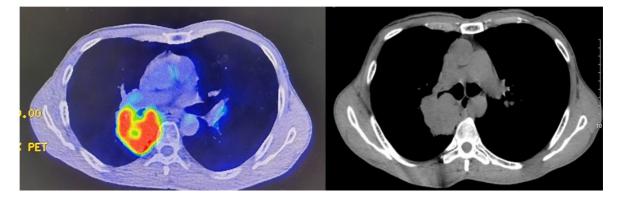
PET -CT and CT chest images before treatment
